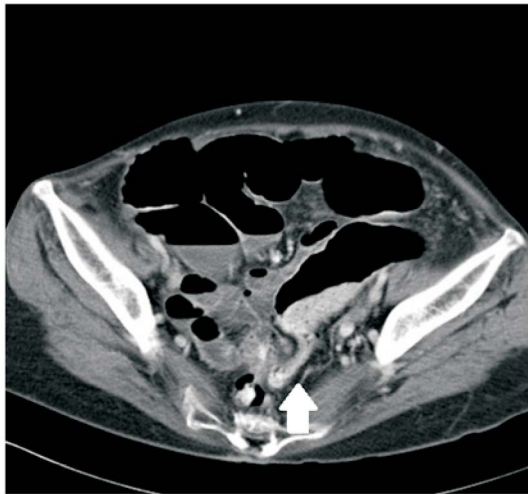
Contrast-enhanced computed tomography of the abdomen showing a discrepancy in the caliber of the sigmoid colon and the upper rectum (arrow).
